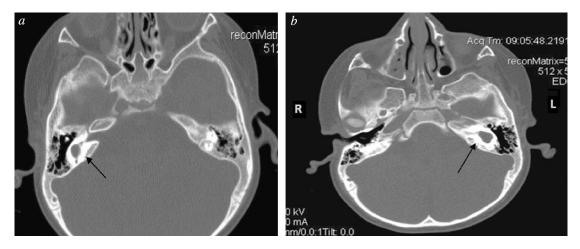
Computed tomography child T. Inner ear malformation: common cavity a) right; b) left.
